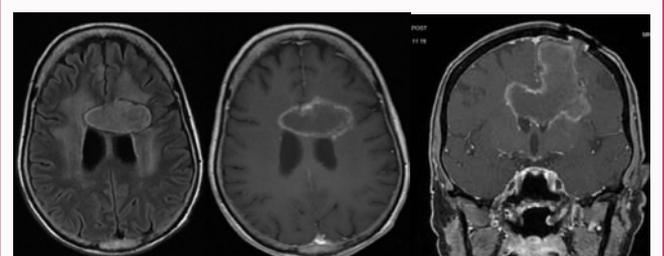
MRI dated 5/14/2020 demonstrating 5.3 cm × 3.1 cm × 5.8 cm (transverse × anteroposterior × craniocaudal) lesion. Sequences are (from left-to-right) axial T2 FLAIR, axial T1 post-contrast, coronal T1 post-contrast.
